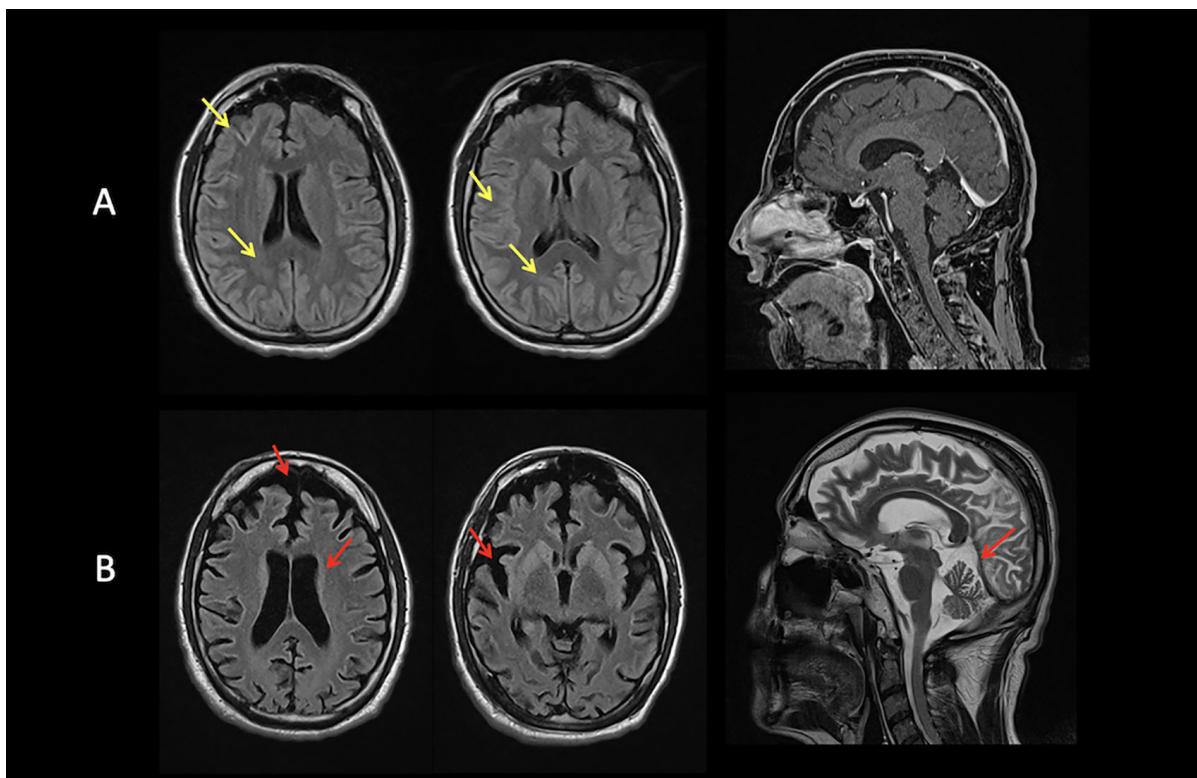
MRI studies from Patient 1. (A) At age 37 years: T₂-FLAIR subcortical hyperintense non-enhancing foci localized to the frontal, temporo-occipital and visual cortices bilaterally with prominent involvement of calcarine cortex (yellow arrows). (B) At age 38 years: severe and diffuse cortical and subcortical atrophy (red arrows).
